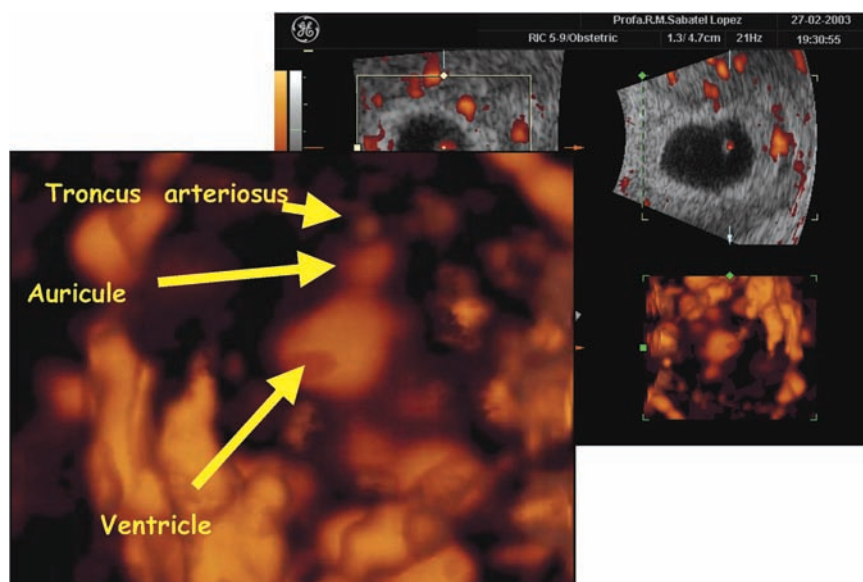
Morphology of the heart at the fourth week of development with 3D PW Doppler.
